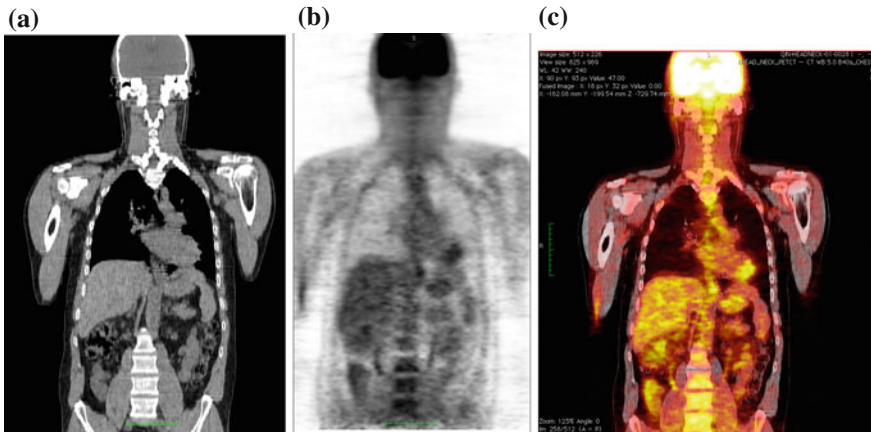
PET/CT images: a CT image; b PET image; c Fused PET/CT image
